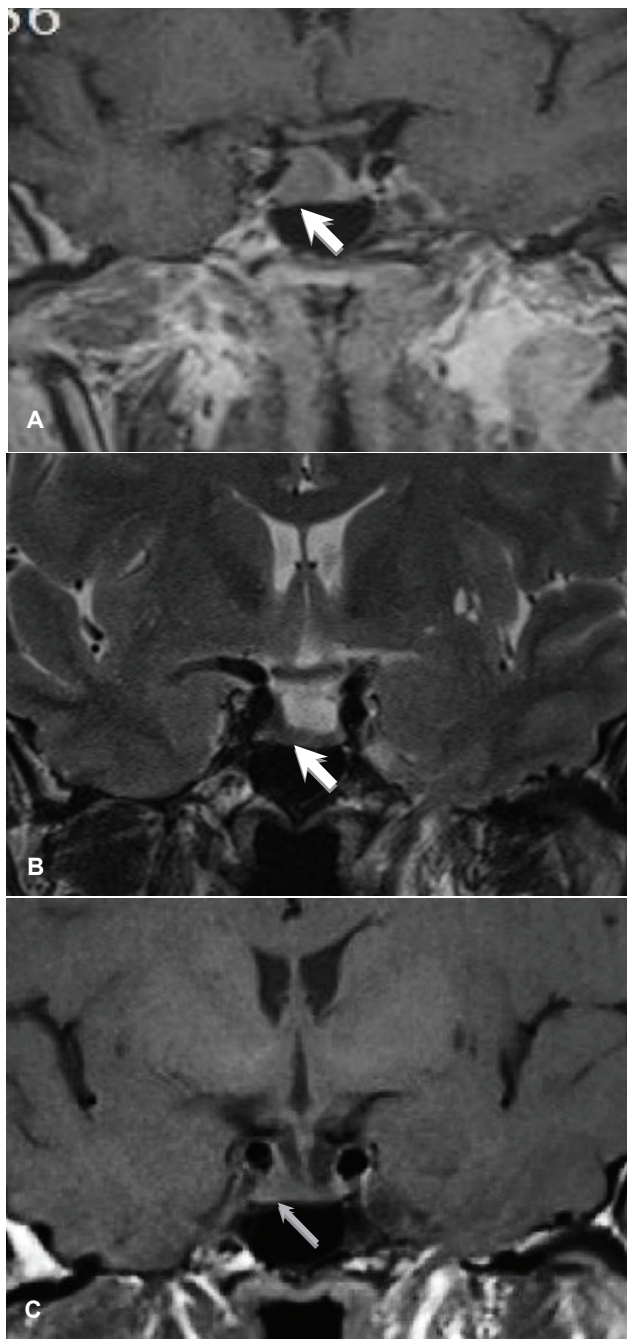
MRI of the pituitary gland, coronal view. (A) T1-weighted initial study showed a 1.5 cm x 1.6 cm x 1.1 cm adenoma (*white arrow*) on the right side of the pituitary invading the right cavernous sinus and encasing the right internal carotid artery. (B) on T2-weighted imaging, the tumor appeared hypointense, suggestive of dense granulation. (C) follow-up study showed reduction in size of the pituitary adenoma to 0.5 cm x 0.6 cm x 0.3 cm (*thin gray arrow*) after 6 months of octreotide LAR.
